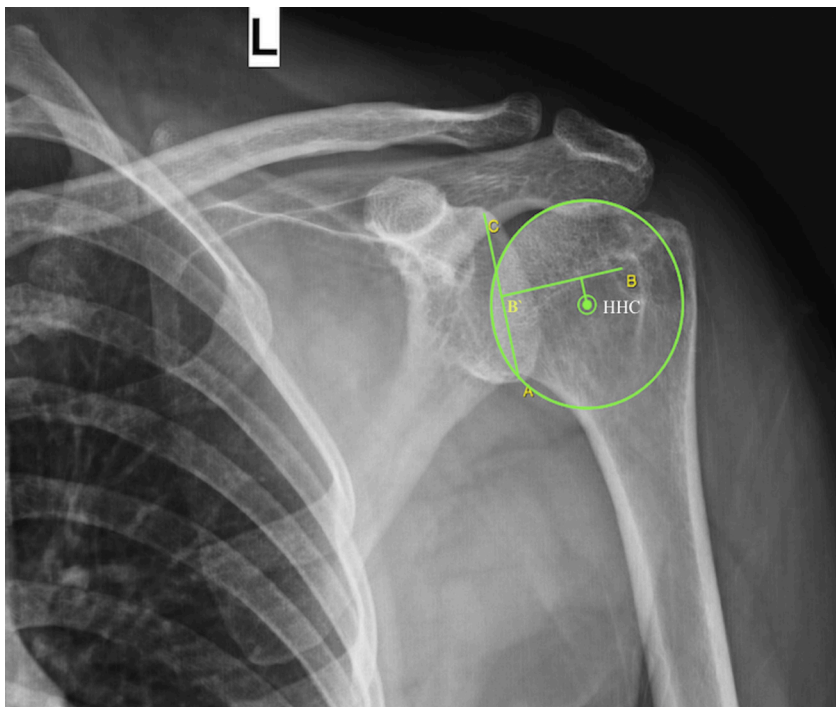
Anteroposterior shoulder radiography demonstrating center equator distance. Values were considered negative when humeral head center was below the glenoid equator line and positive when it was above this line.
